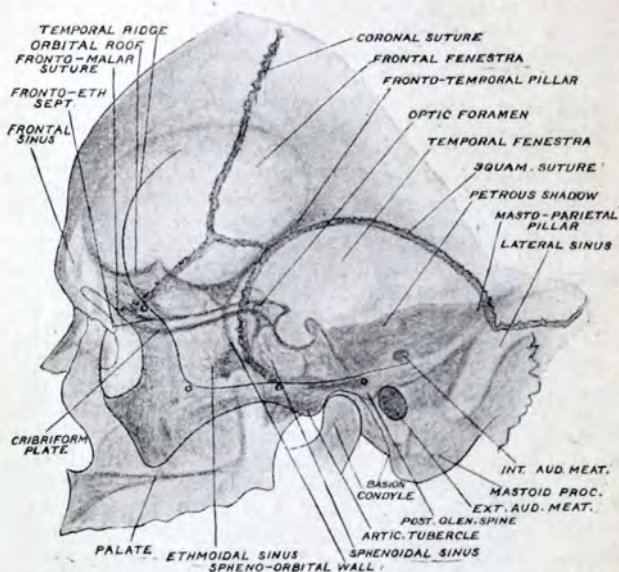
Structures seen in the temporal region when the skull is examined in profile by means of X-rays.
